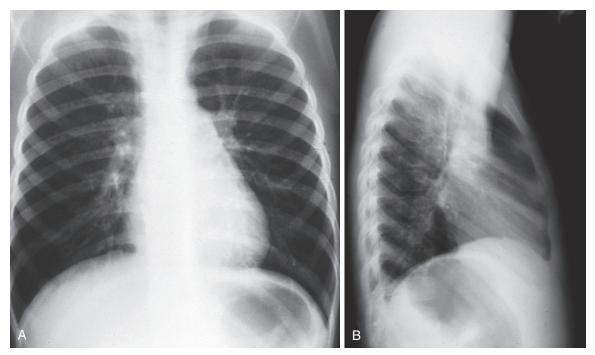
Normal posteroanterior (A) and lateral (B) chest radiographs of a 6-year-old child.
